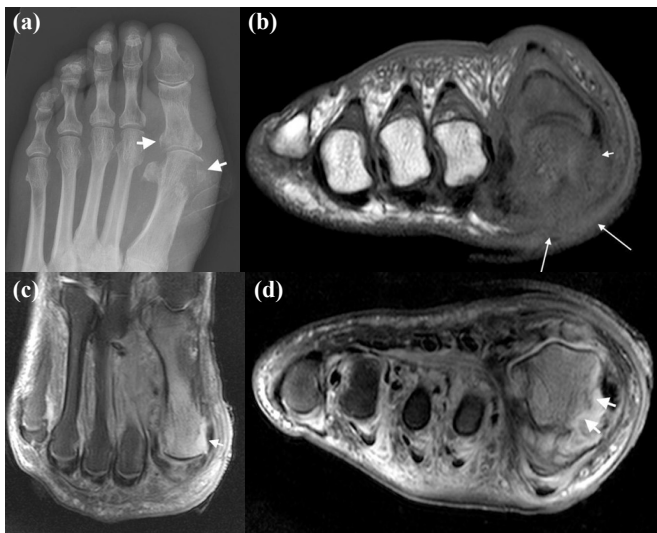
(a) Plain x-ray showing erosion of medial margin of first metatarsal head and lateral margin of base of first proximal phalanx (short arrows) representing osteomyelitis. (b) MRI Short axis T1 showing a large ulcer (long arrows) on the plantar aspect of the first MTP joint with erosion of the first metatarsal head (short arrow). (c) MRI Long axis T2 FS (fat-suppressed) showing an ulcer of the first metatarsal head (short arrows) along with marrow oedema of the metatarsal shaft. (d) MRI Short axis T2 FS showing an ulcer of the first metatarsal head (short arrows) along with marrow oedema of the metatarsal shaft. MRI did not change management of this patient.
